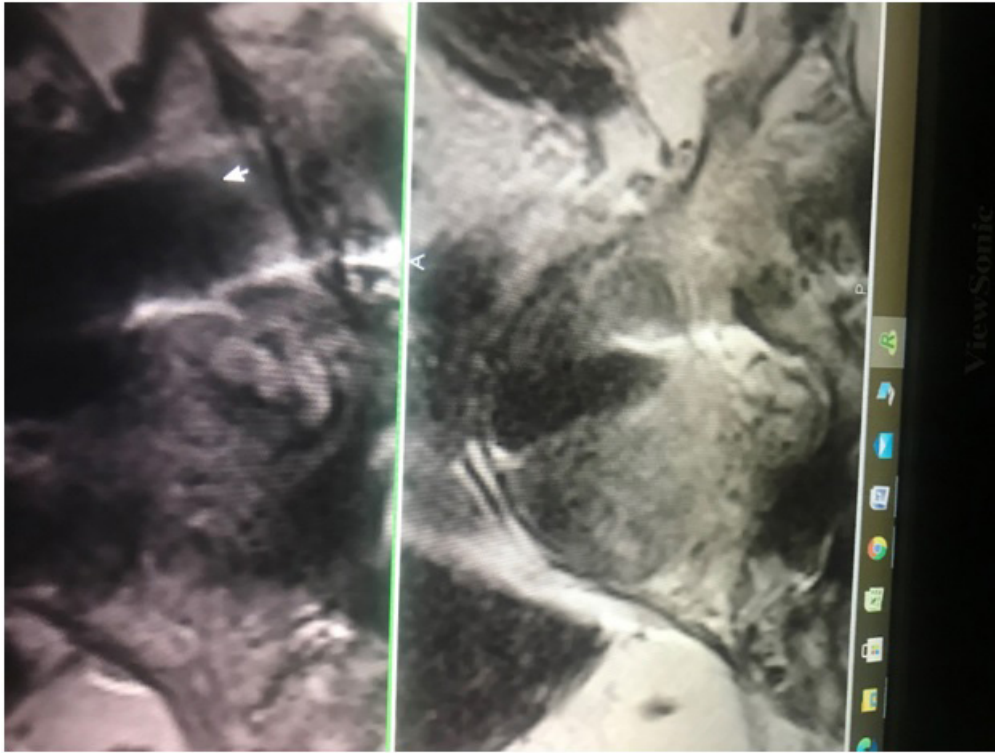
This is despite the appearance of her most recent lumbar MRI scan which is grossly abnormal.
